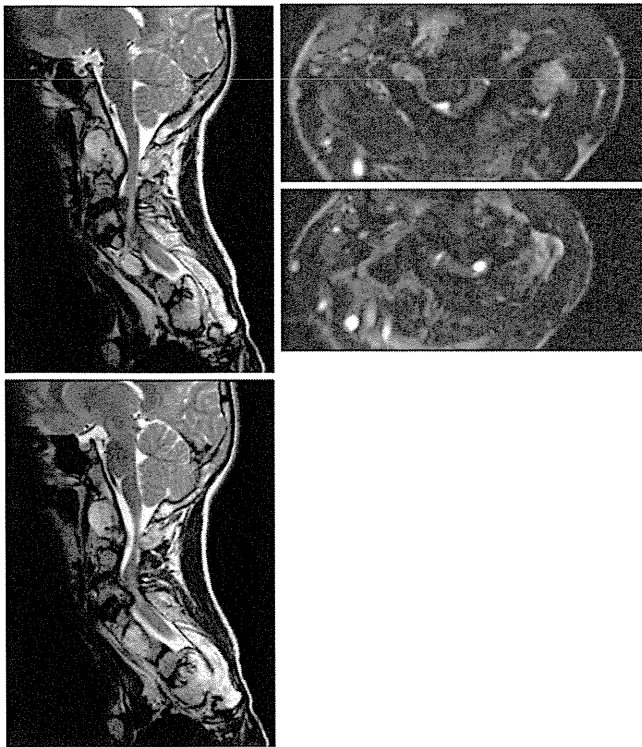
Sagittal T2-weighted MR images showed spinal cord compression by the protruding bone at C2/3 and C3/4 level. High intensity of the spinal cord was observed in the axial view
